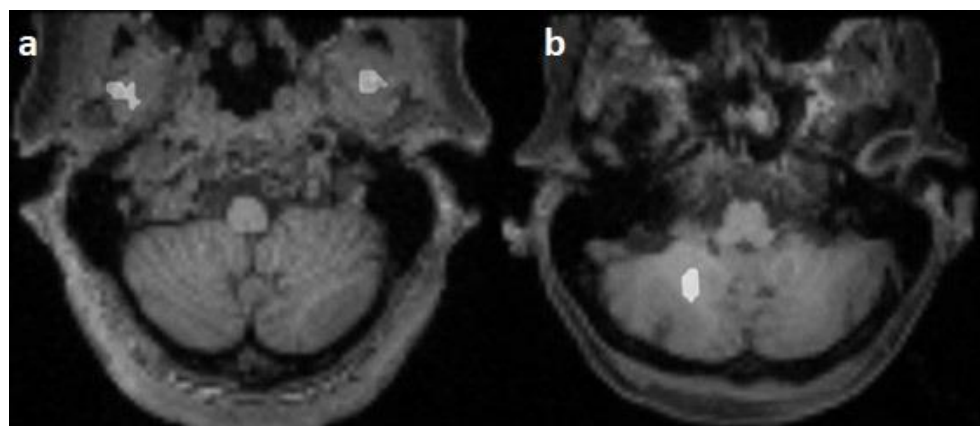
Falsely segmented areas (white) on horizontal T1-weighted images: mm. pterygoidei (a) and cerebellum (b).
